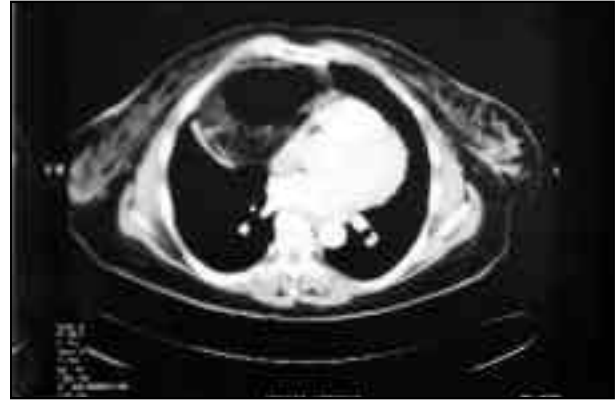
CT scan showing omentum and transverse colon in the thoracic cavity
